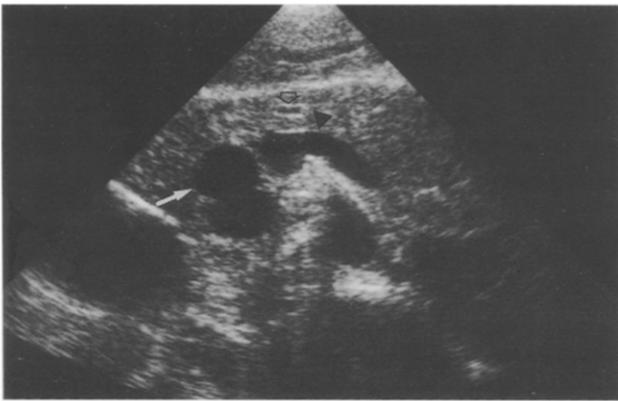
Post-contrast ultrasound image (transverse plane) of the pancreatic head and body showing significant dilatation of the distal common bile duct (arrow) with no evidence of stones. Also depicted well are the splenic vein (arrowhead) and the pancreatic duct (open arrow).
